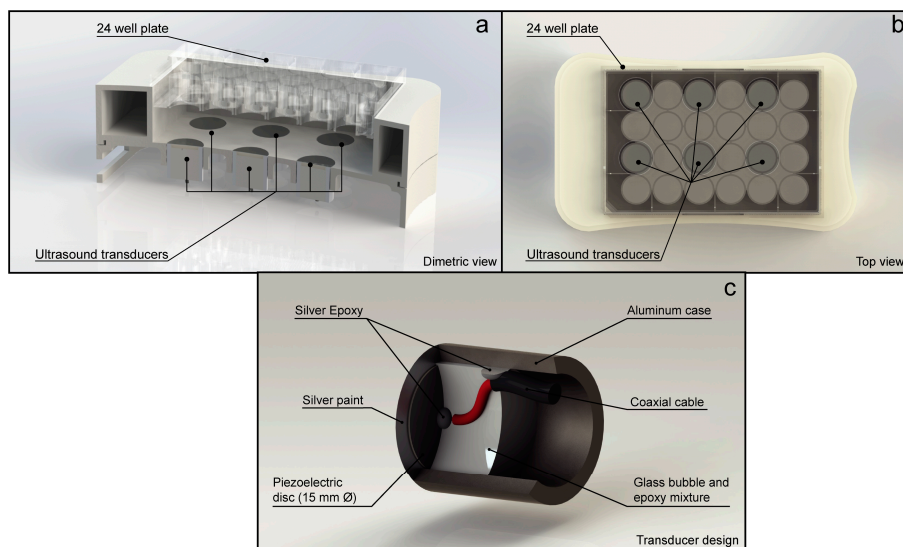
Ultrasound treatment chamber and transducer design used to treat the cells. (a) Cutaway of the dimetric view of ultrasound treatment chamber showing the distance. (b) Top view of the chamber showing which cell culture wells were exposed to ultrasound. (c) Cutaway of the transducer design used in the ultrasound treatment chamber.
